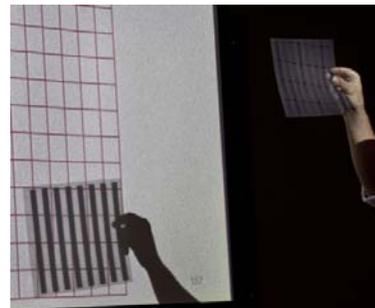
(top) A chest radiograph on a transparency is shown in front of a projected grid pattern representing the pixels of a digital detector. (bottom) The continuous “x-ray beam” containing the information of the chest x-ray is then projected using a transparency with the array of “pixels” overlaid, followed by the result of the coarsely sampled image.
